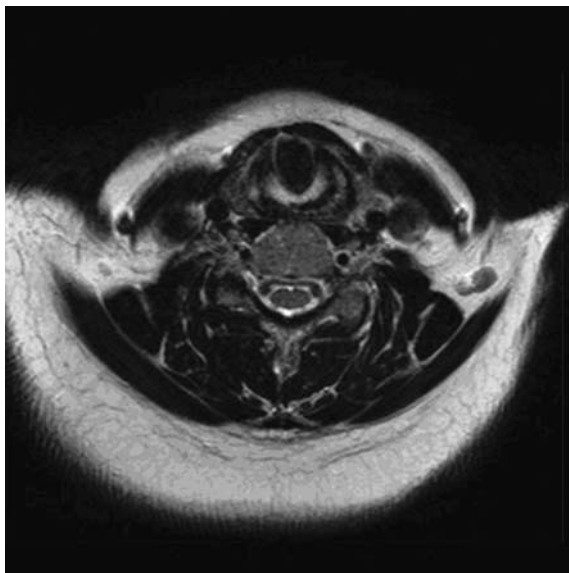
Axial T2 weighted MR image shows no evidence of recurrence after 17 months.
